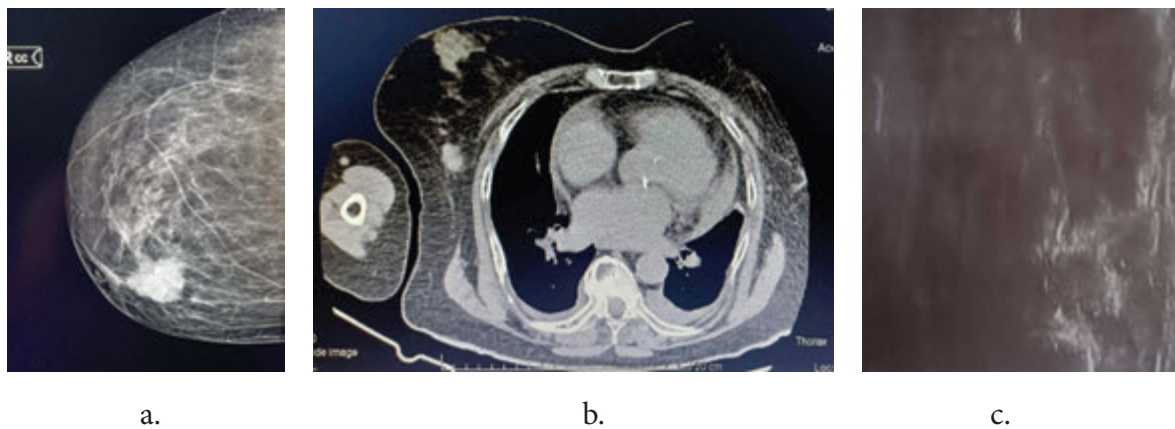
(a). Mammography showed retroareolar hyperdense multilobulated mass; (b.) Thoracic CT showed left-sided pleural and pericardial effusions, with evidence of cardiomegaly; (c.) ultrasound confirmed a hypoechoic subcutaneous irregular lesion.
